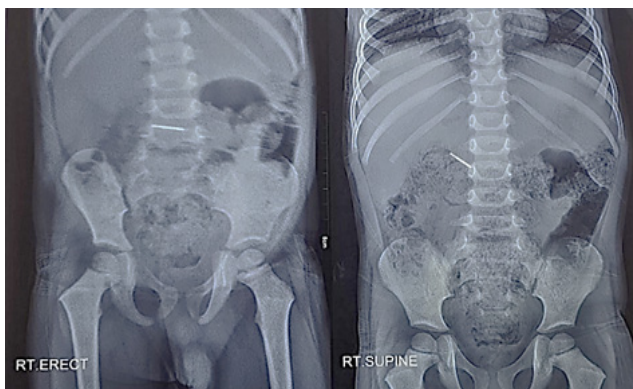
Immediate chest and abdominal radiograph showing the evidence of bur in stomach.
